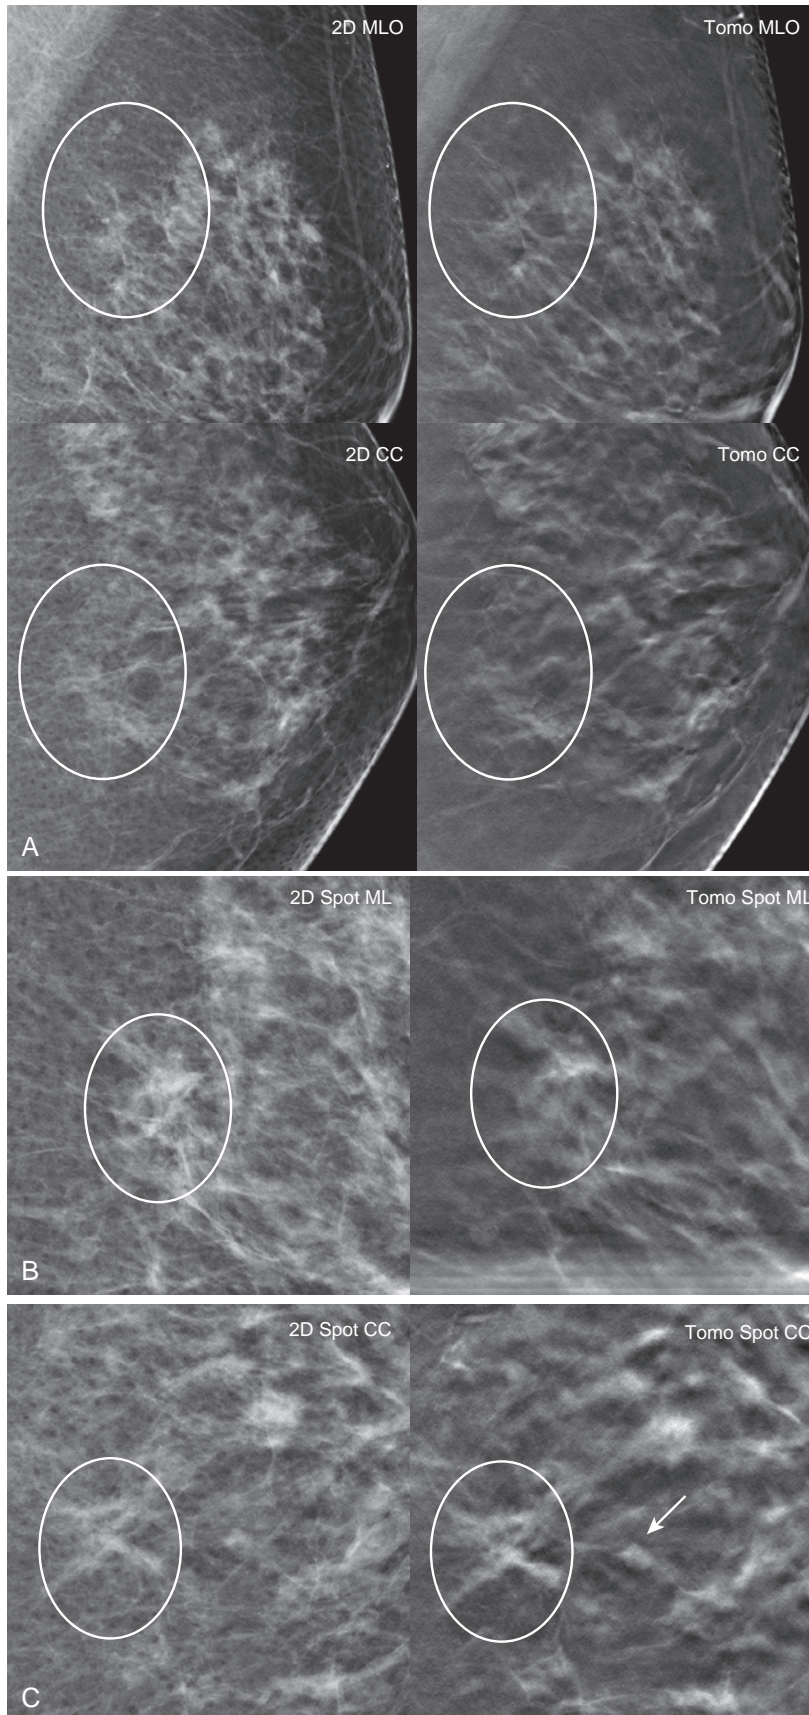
Architectural distortion initially much better visualized on tomosynthesis. (A) Screening mammogram in a 62-year-old woman with scattered fibroglandular tissue reveals a subtle AD seen only the tomosynthesis MLO view (*circle*). On the 2D MLO view, only a corresponding asymmetry is seen, which could easily be dismissed as normal fibroglandular tissue. (B and C) Combination 2D and tomosynthesis spot compression views were obtained, which demonstrated that the distortion (*circles*) was most obvious in the CC view with tomosynthesis. (D) No ultrasound correlate was found and stereotactic core needle biopsy was performed in the CC projection utilizing a nearby probable cyst (*arrow*) as a guiding landmark. Stereotactic core needle biopsy and excision = 6 mm grade 1 tubular IDC, ER+, PR-, Her2-, 0/2 SLN.
